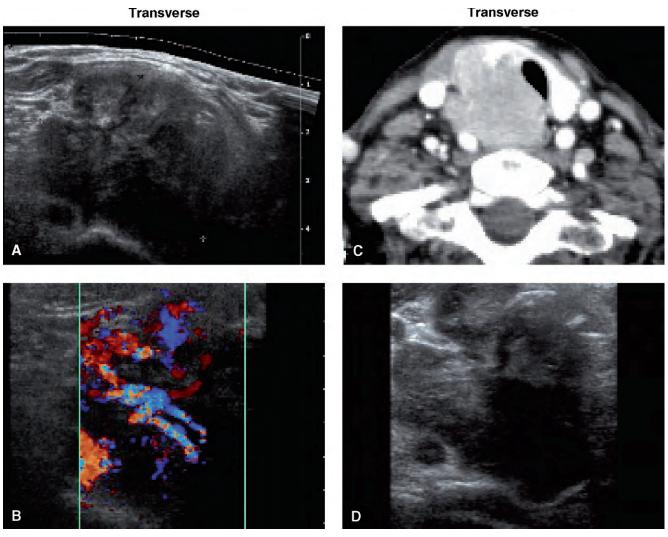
Ultrasound (US) of anaplastic carcinoma in the right lobe. A, Transverse, 32 x 42 mm. B, Color Doppler, transverse. C, Transverse CT. D, Transverse.
